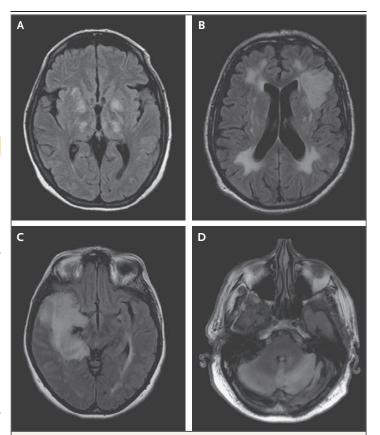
MRI Patterns in Patients with Viral Encephalitis.
